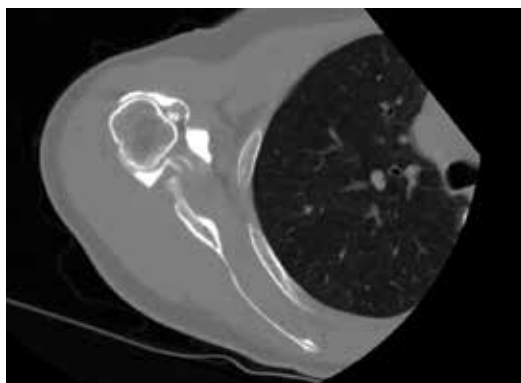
Axial view of computed tomography arthrogram showing a medial subluxation of the LHBT, related to a SSC tear.
